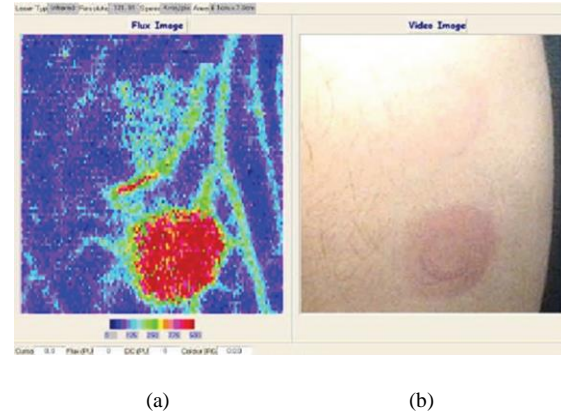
(a) Laser Doppler imager (LDI) captures images for human skin after applying two different doses of UVB irradiation, and erythema was induced. (b) the corresponding color image of the induced erythema [66].
